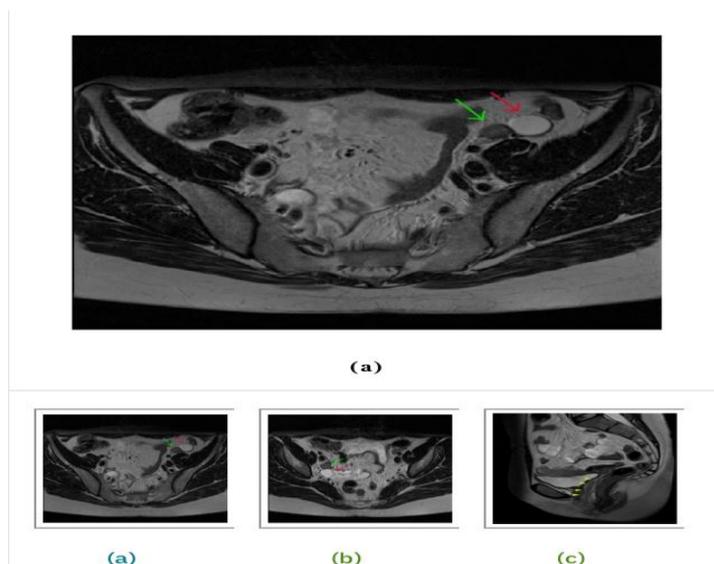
MRI scan exam of female with CAIS.
